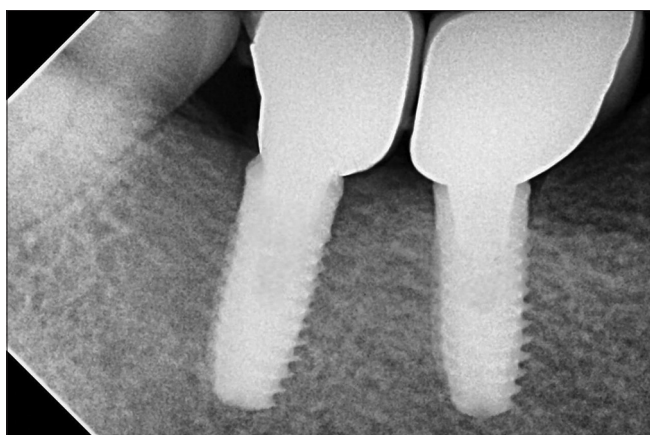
Postoperative IOPA X-ray wrt 46, 47
